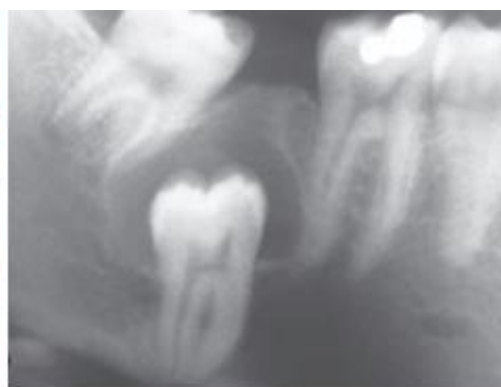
Radiographic presentation of dentigerous cyst
